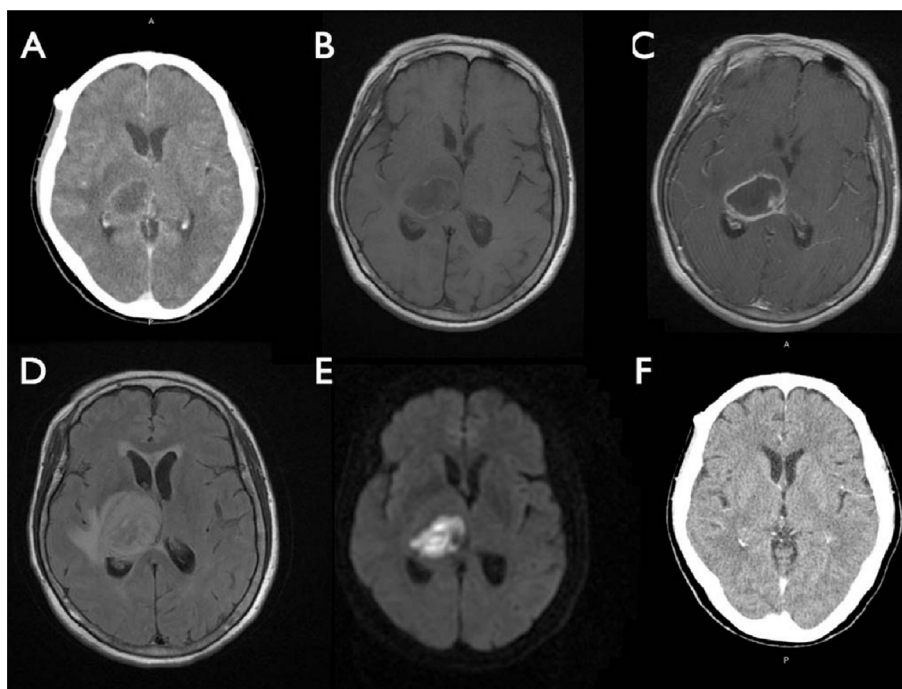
(A) Computed tomography (CT) with contrast at presentation shows one ring-enhanced cystic lesion at the right thalamus, 3 cm in the largest diameter; (B) magnetic resonance imaging (MRI) T1 without contrast; (C) MRI T1 with contrast; (D) MRI T2 fluid attenuation inversion recovery; (E) MRI diffusion-weighted imaging taken 6 days after antibiotics treatment shows one ring-enhanced cystic lesion at the right thalamus with diffusion restriction, 3.5 cm in the largest diameter, and its edema involving the upper midbrain, indicating possible failure of antibiotics treatment or abscess growth; (F) CT with contrast after 8-week antibiotics treatment shows complete remission of the abscess.
